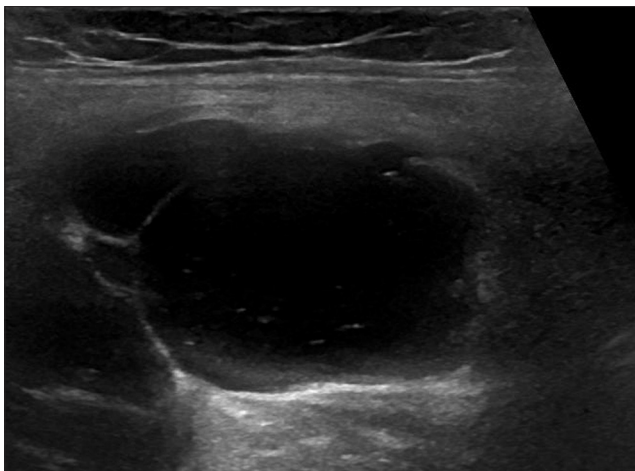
Ultrasonography: Cystic formation
